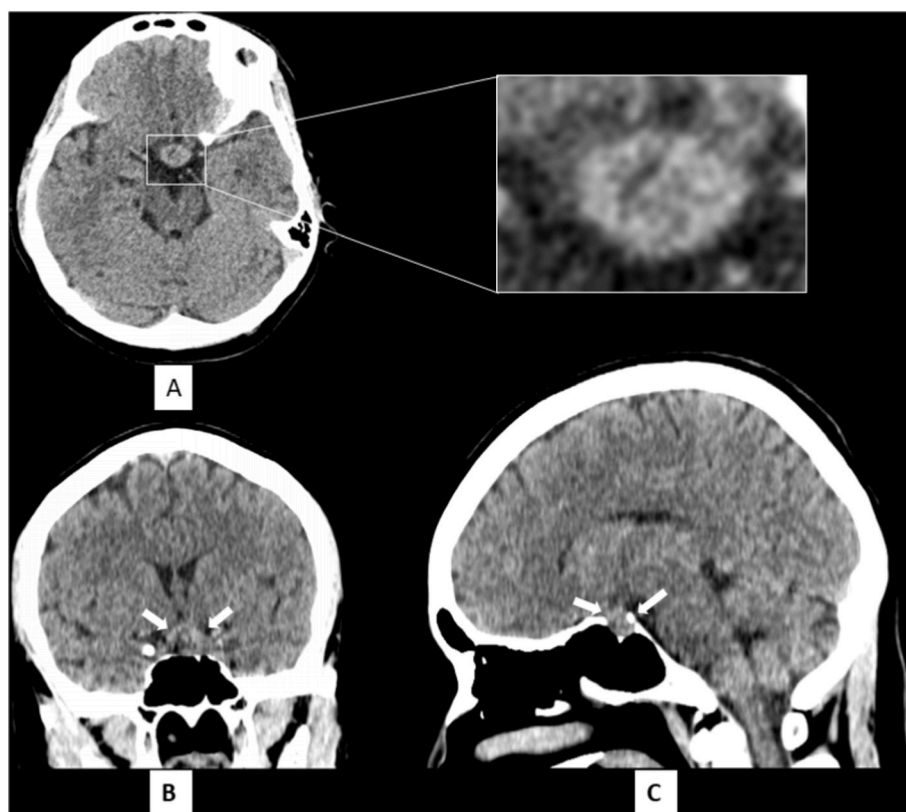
Non contrast-enhanced CT Brain in axial view (A) with accompanying magnified image of the high density sellar lesion with hypodensity within. The coronal reconstructed view (B) and sagittal reconstructed view (C) demonstrates the lesion (white arrows) to occupy the whole of cavernous sinus with pressure remodelling of the floor or sella turcica. The images suggested a sellar mass and differential diagnosis at this point of time includes pituitary adenoma.
